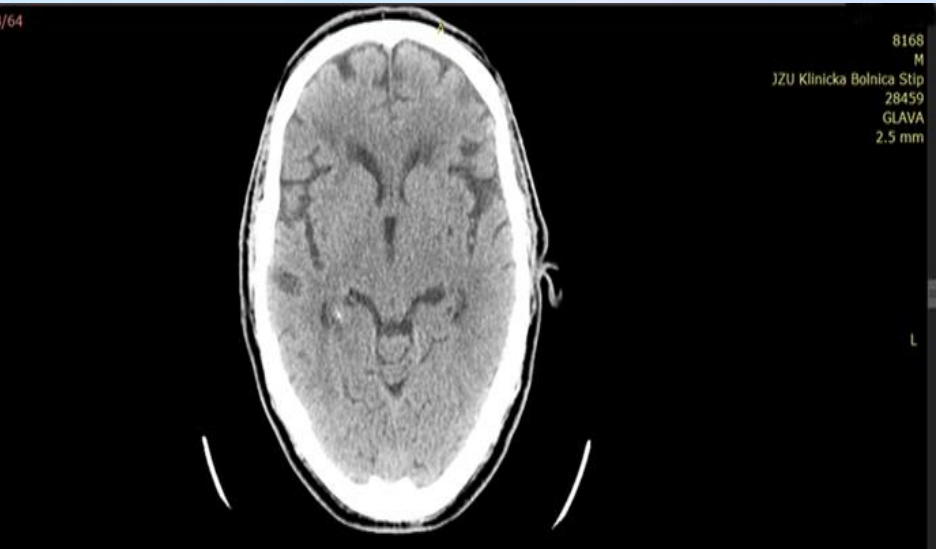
/ CT showing widespread cortical atrophy, ventricular enlargement, vasculopathic changes in the basal ganglia, and encephalopathic alterations
